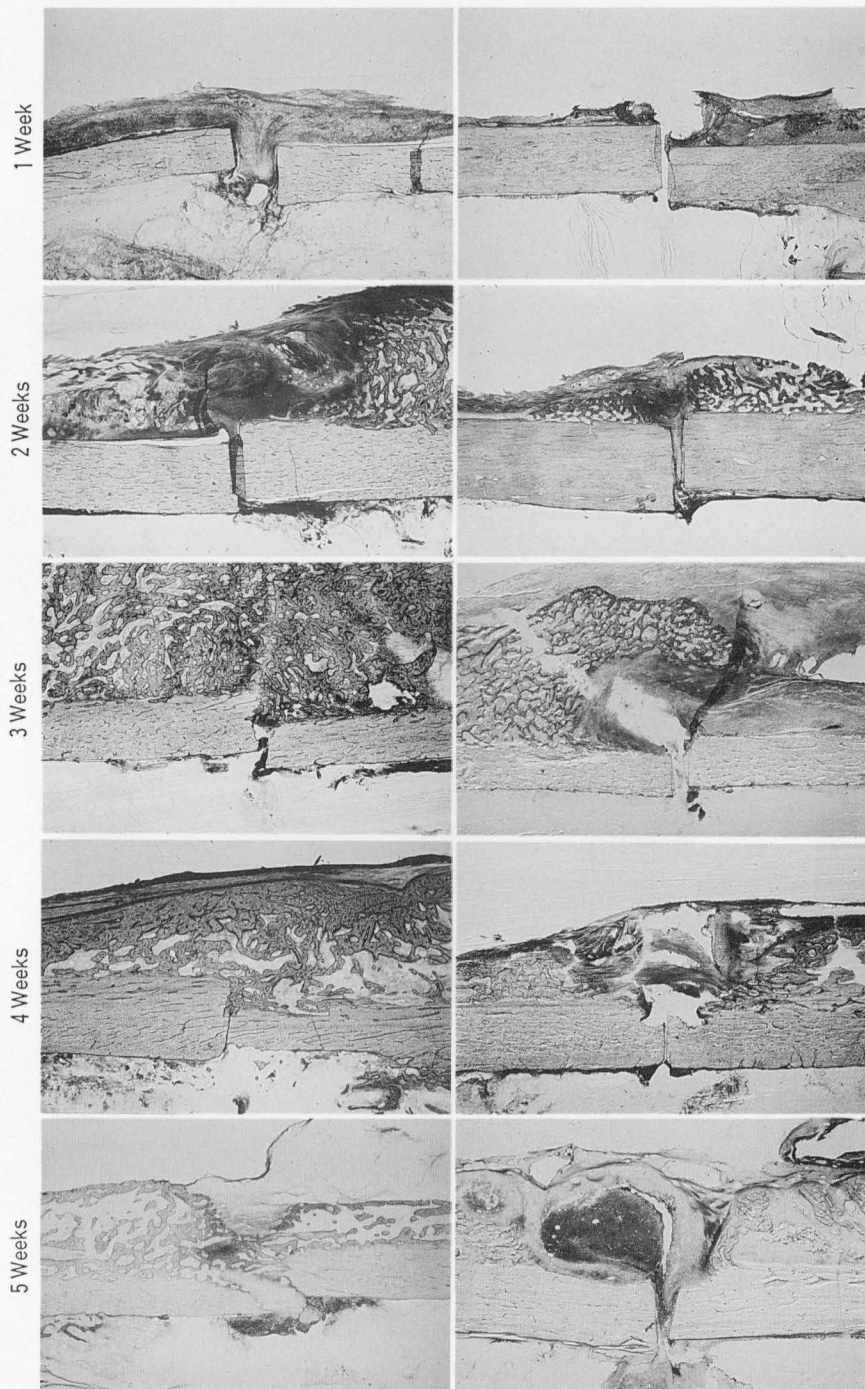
Soft x-ray findings on fracture healing
